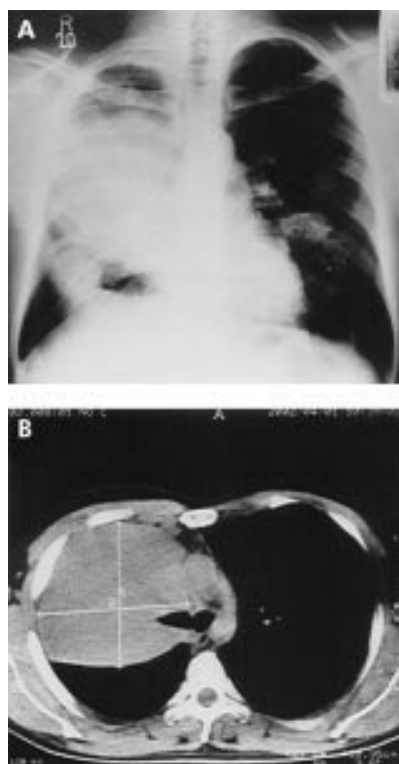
(A) Posteroanterior chest radiograph showing a bulky mass in the right lung, a smaller mass in the lower zone of the right lung, and heterogeneous infiltration in the middle zone of the left lung. (B) CT scan of the chest showing a bulky mass in the right lung.
